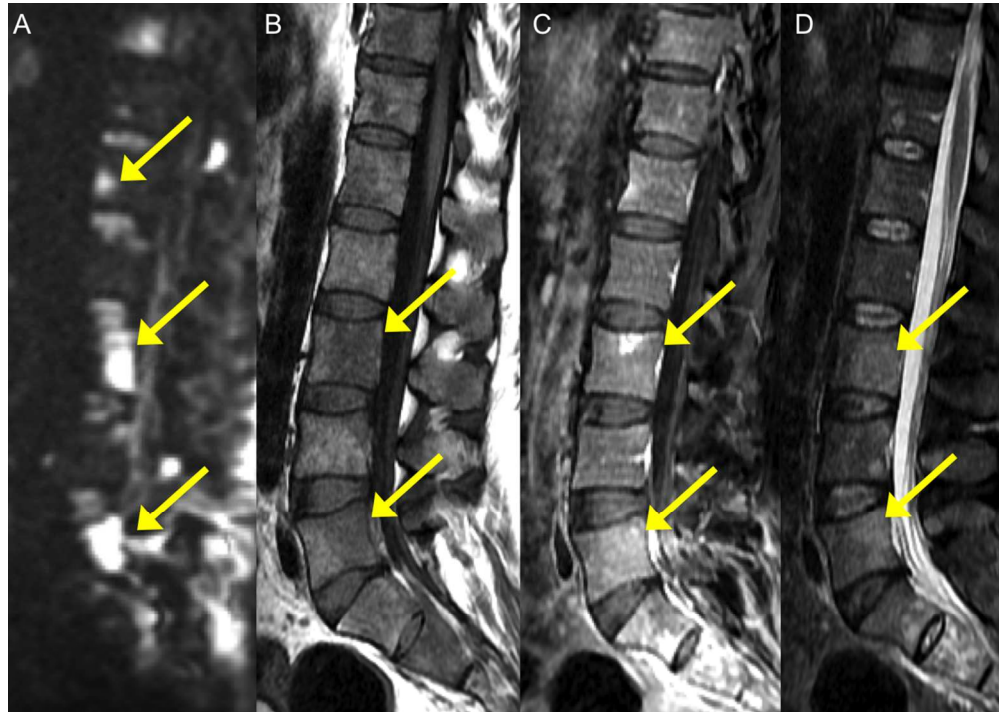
59 year-old male with lung cancer and metastatic vertebral lesions. Lesions demonstrate high intensity and high conspicuity on high b value DWI (b1000, arrows) (A) and appear hypointense on T1WI (B), minimally enhancing on T1 post-contrast (C), and moderately hyperintense on T2 WI (D).
